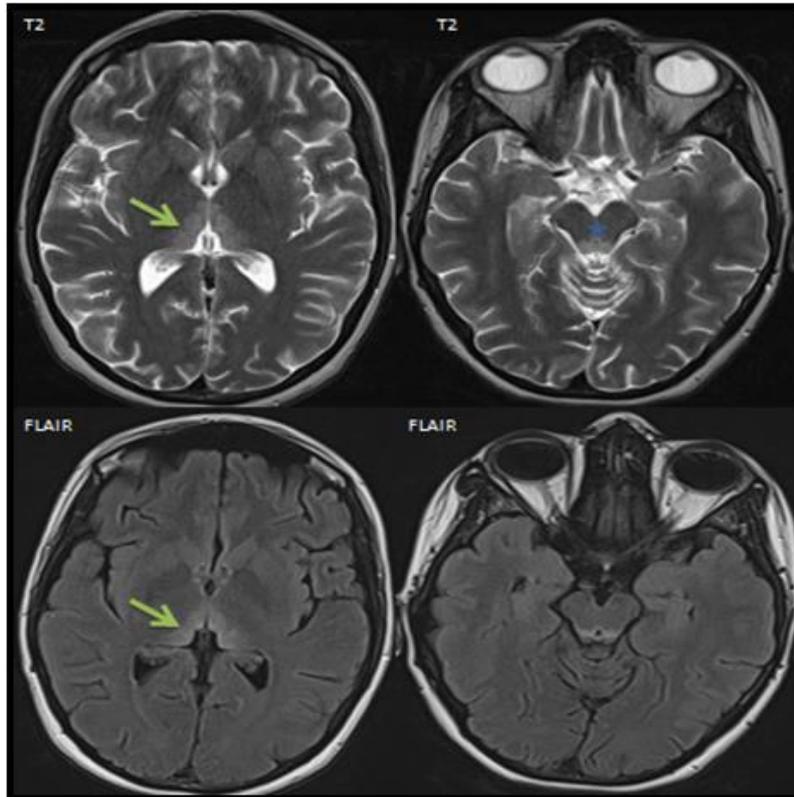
Axial fluid-attenuated inversion recovery (FLAIR) and sequence T2 weighted images from when the patient was encephalopathic show symmetrical changes of abnormal high signal in the periaqueductal area (asterix), and posterior medial thalami (arrows).
